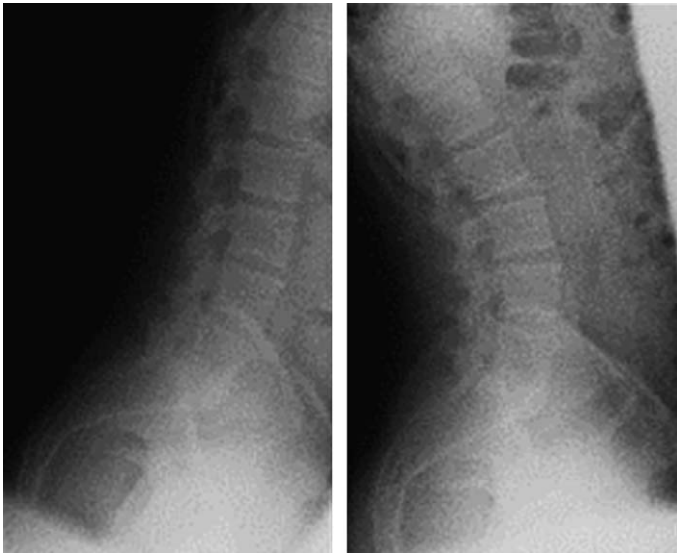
Postoperative flexion-extension plain films of a patient who has undergone a laparoscopically assisted ALIF using bone morphogenic protein and allograft bone plugs. Despite the relatively less aggressive disc space preparation classically used with the laparoscopic approach, a solid interbody fusion has been achieved.
